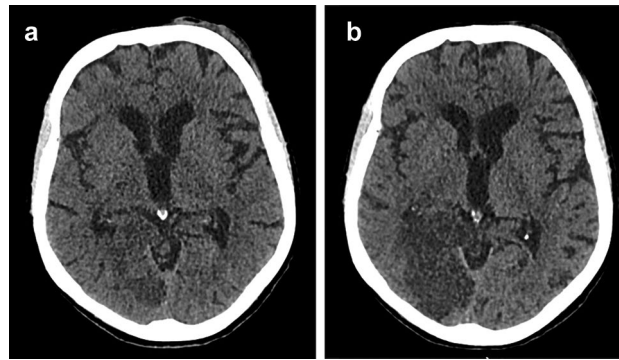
Representative figure of a CT scan of an 80-year-old COVID-19-positive patient with a history of hypertension and diabetes, presented at the ER reporting headache and fall after vertigo and loss of balance. A left hemiparesis was evident. a Ischemic stroke in the distribution of the right posterior cerebral artery (hypodense imaging and blurring of gray-white matter) at the day of presentation. b Three days later. COVID-19, coronavirus disease 2019; CT, computed tomography.
